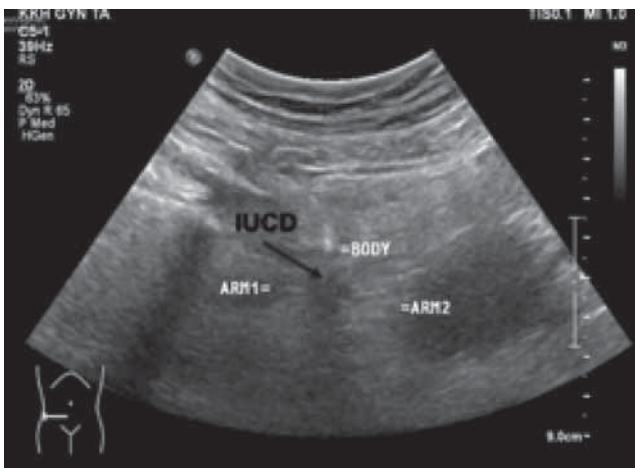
Pelvic ultrasound – extra-uterine IUCD in the right adnexal region with trace amount of fluid and mildly echogenic fat
